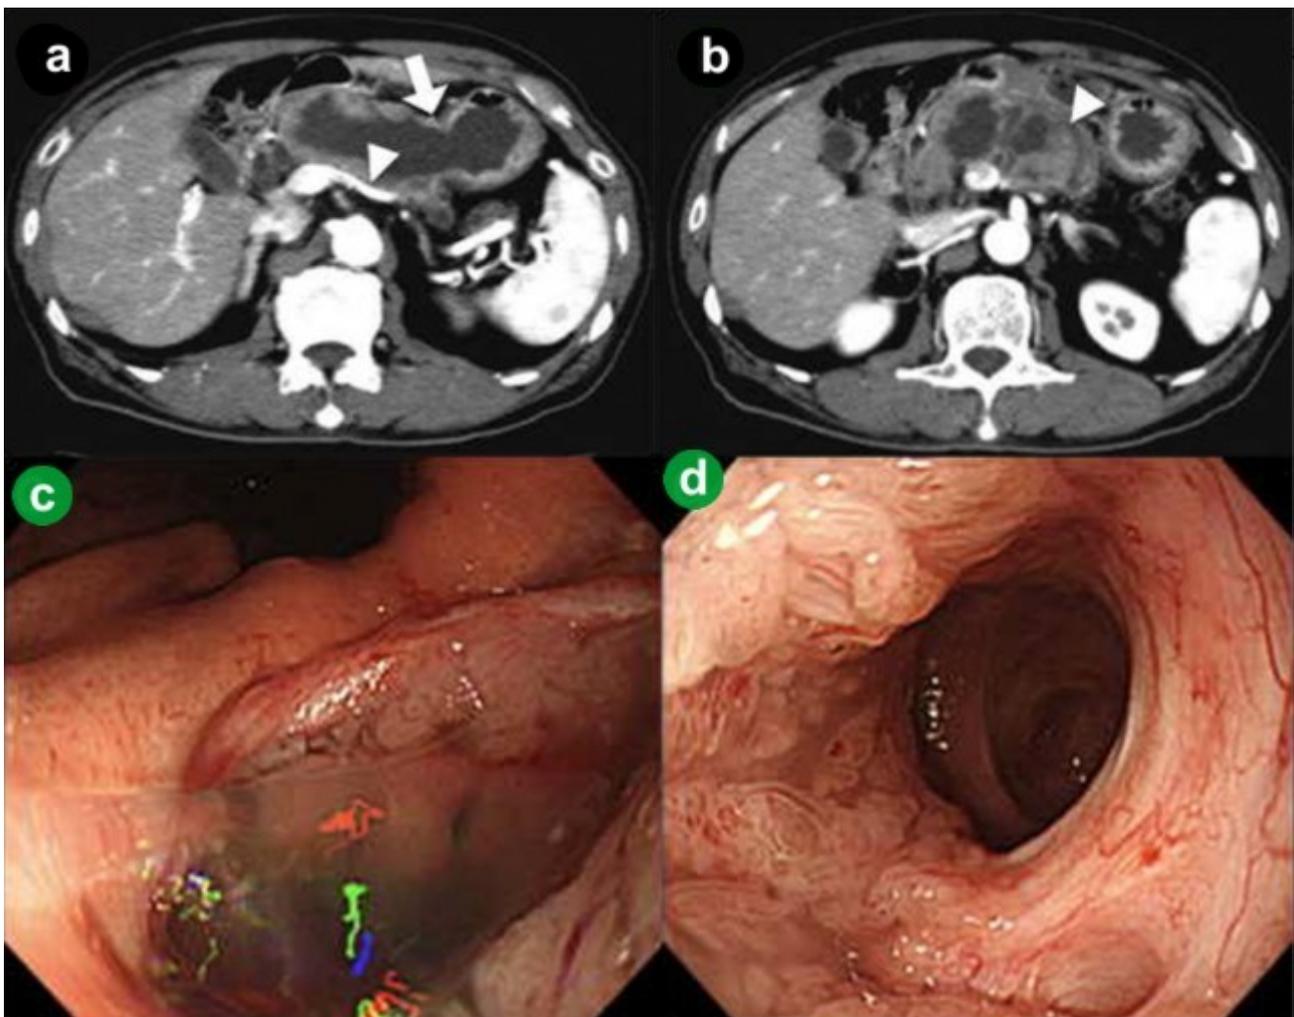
a. Computed tomography (CT) showed the main pancreatic duct penetrating to the stomach (arrow) and reperfusion of the splenic vein (arrowhead). b. CT showed increased size of the papillary tumor in the main pancreatic duct. c. Gastroduodenoscopy showed gastropancreatic fistula on the lesser curvature of the middle gastric body. Mucus was discharged from the fistula. d. Suction of the mucus enabled us to pass an endoscope into the dilated main pancreatic duct through the fistula and directly examine the lumen of the main pancreatic duct and the papillary tumor adjacent to the fistula.
